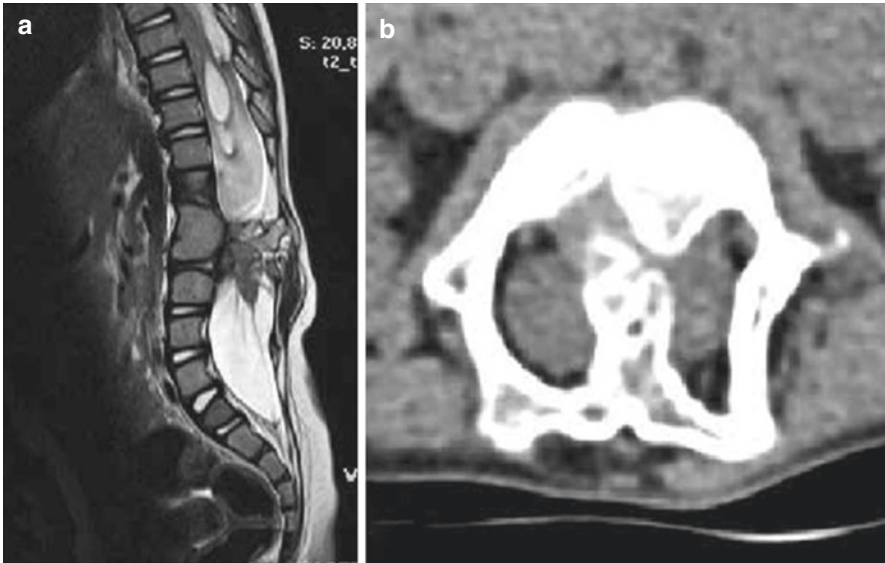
(a) T2-weighted sagittal MRI images of an SCM patient. (b) Axial CT scan shows a midline osseous spur
